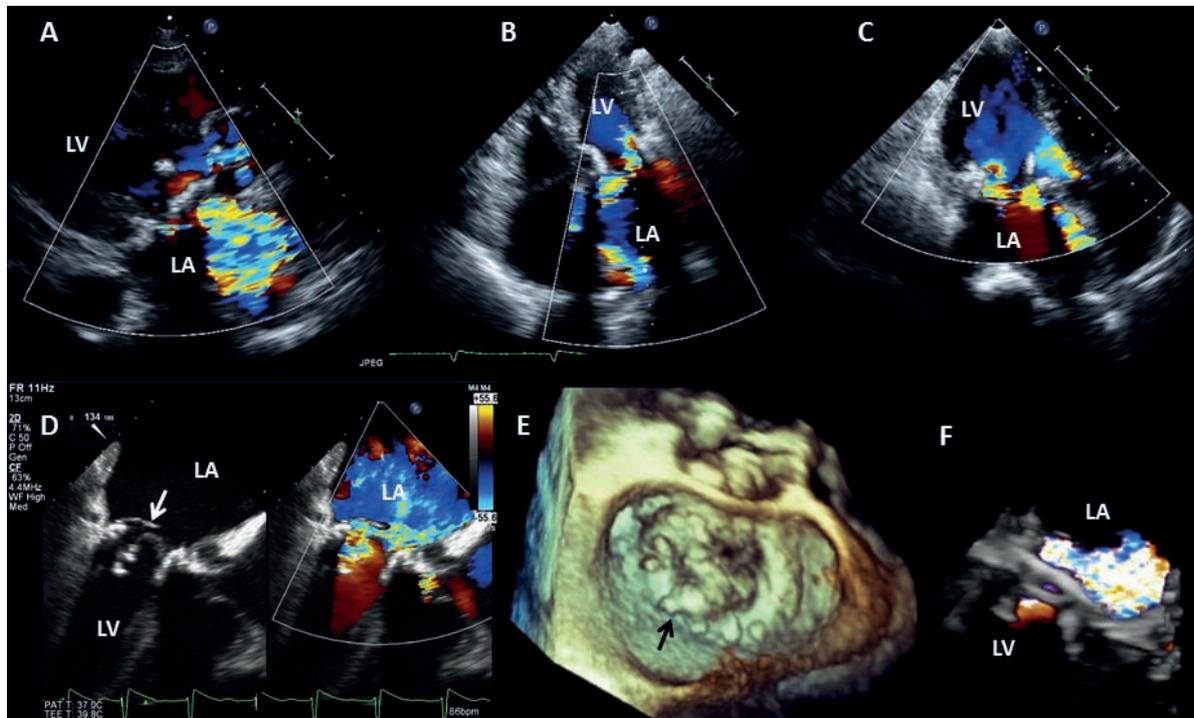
Bioprosthetic mitral valve with severe regurgitation due to valve degeneration. Top row: Transthoracic color Doppler images in the (A) parasternal long axis, (B) four-chamber, and (C) three-chamber view showing severe bioprosthetic mitral valve regurgitation with a varying amount of shadowing from the valve struts. Bottom row: Transesophageal echocardiographic images from the same patient. (D) Mid transesophageal long-axis view demonstrating a flail mitral cusp (arrow) along with severe mitral regurgitation on color Doppler. Three-dimensional images (E) also show the flail cusp along with (F) severe regurgitation.
